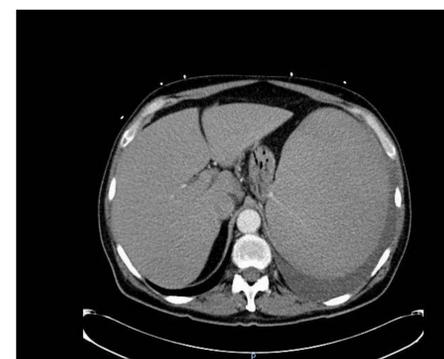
Abdominal CT showing massive spleen 30 x 24 x 12 cm , 3750 grams.
